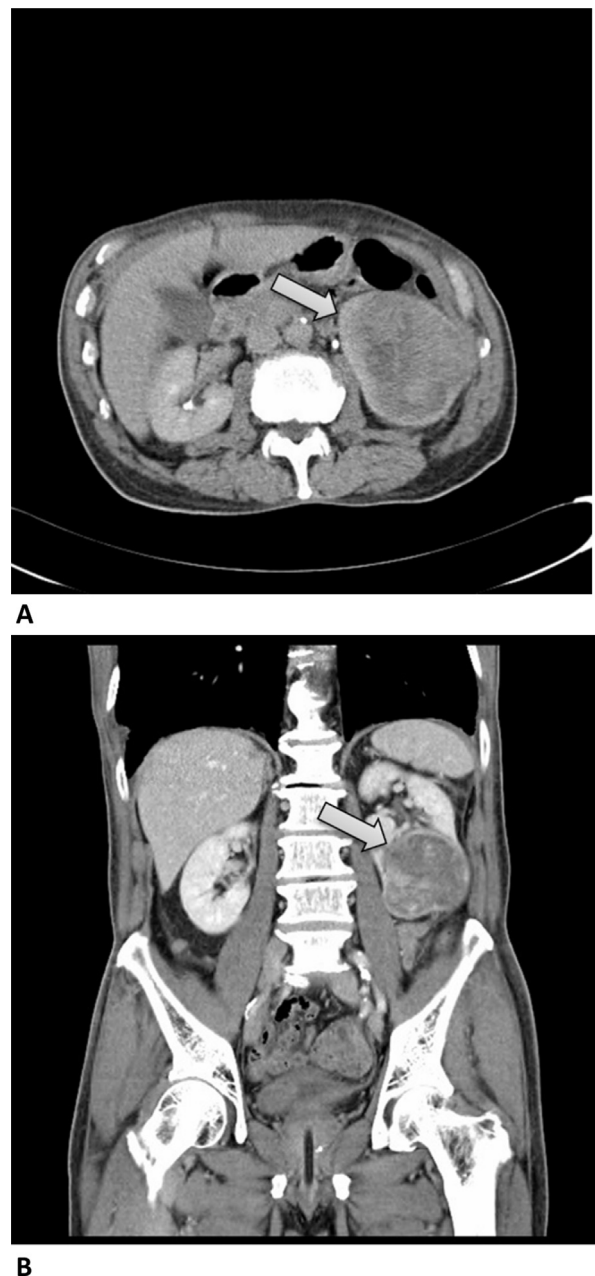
(A) Axial CT scan of the abdomen revealing a large mass (arrow) measuring 8 cm, arising from the lower pole of the left kidney, with features suggestive of renal cell carcinoma. (B) Coronal CT scan of the abdomen revealing a large mass (arrow) measuring 8 cm, arising from lower pole of the left kidney, with features suggestive of renal cell carcinoma. CT = computed tomography.
